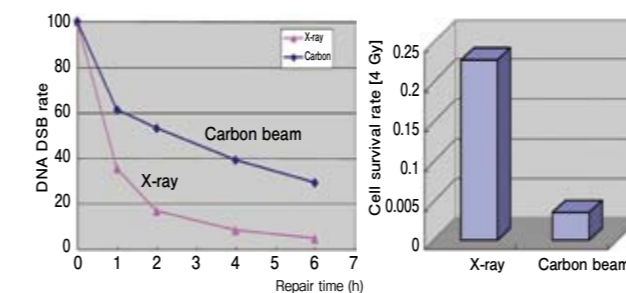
3 Comparison of the DNA DSB repair (left) and cell survival rates (right) after irradiation of prostate cancer cells (DU145) with x-ray and carbon beams (70keV/ $\mu$ m)
